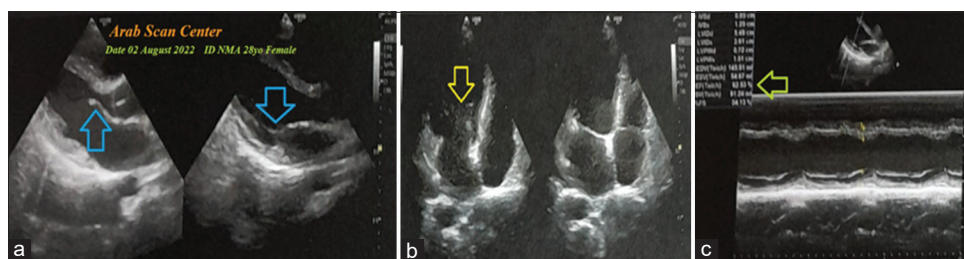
(a-c) Echocardiography was done on the 4th day of the presentation showing a mild thickened tip of anterior mitral valve leaflet prolapse (light blue arrows) and mild mitral regurgitation with eccentric jet (yellow arrow) of an ejection fraction of 62% (lime arrow)
